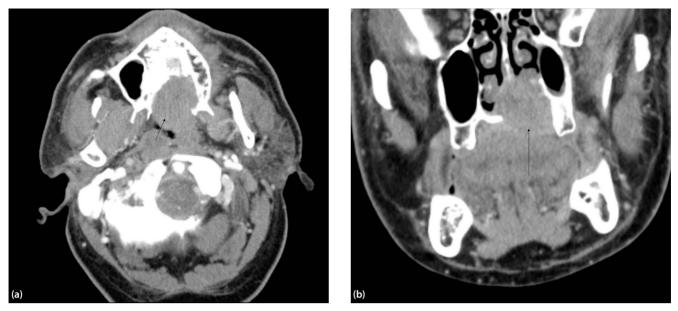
Axial (a) and coronal reformatted (b) contrast-enhanced CT showing left sided destructive hard palate SCC (black arrows) extending into nasal cavity.
